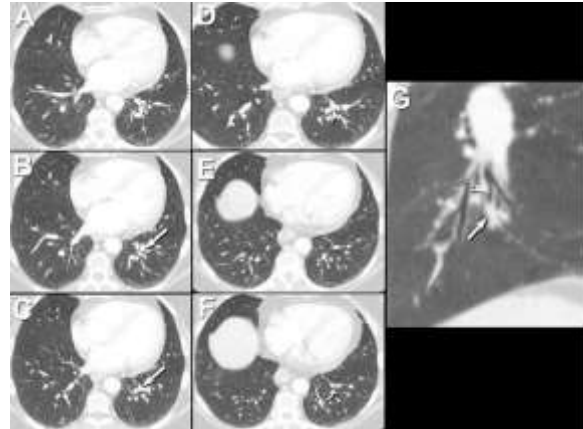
Representative images from the axial enhanced chest CT obtained 6 years following initial presentation and subsequent bilateral adrenalectomy, following recurrence of symptoms suggesting Cushing syndrome.
